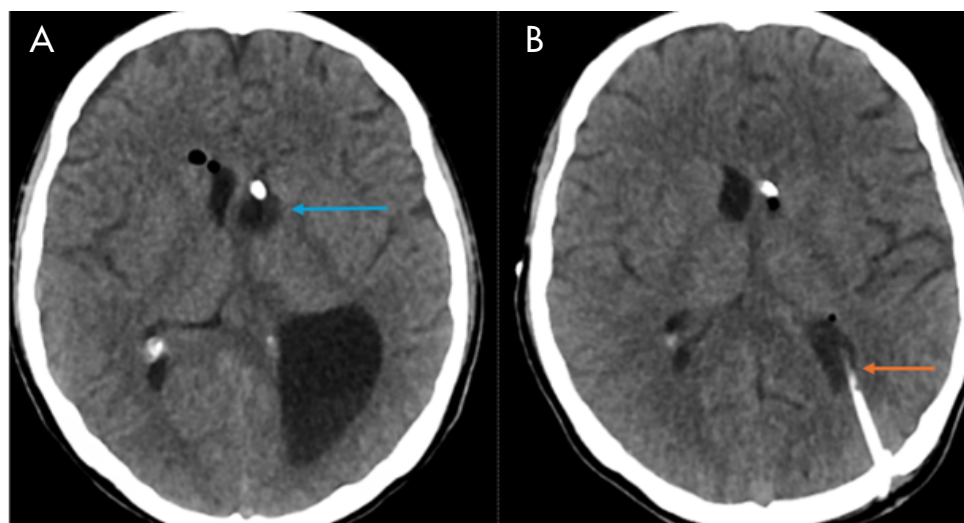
Postoperative non-contrast CT scan of the skull (axial view). A) entrapment of the temporal horn of the left lateral ventricle (arrow); B) external ventricular drain catheter in the temporal horn of the left lateral ventricle (arrow).
